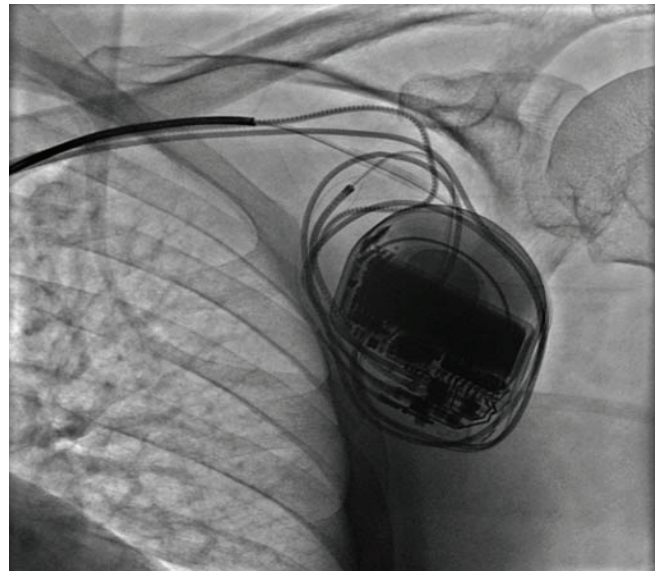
X-ray of the Implant site showing the leads wound around the device
